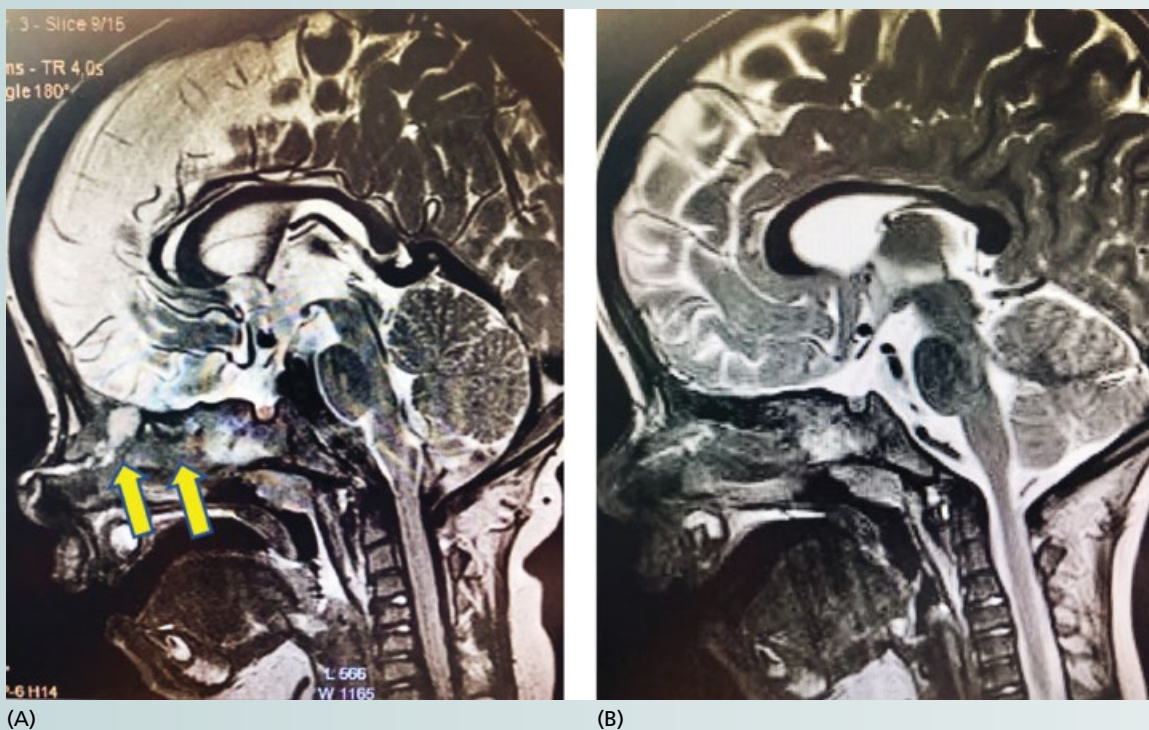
Preoperative (A) and postoperative (B) MRI scans of a dermal sinusoid together with a skull based epidermoid tumor. The arrows in (A) point to the tumor.
